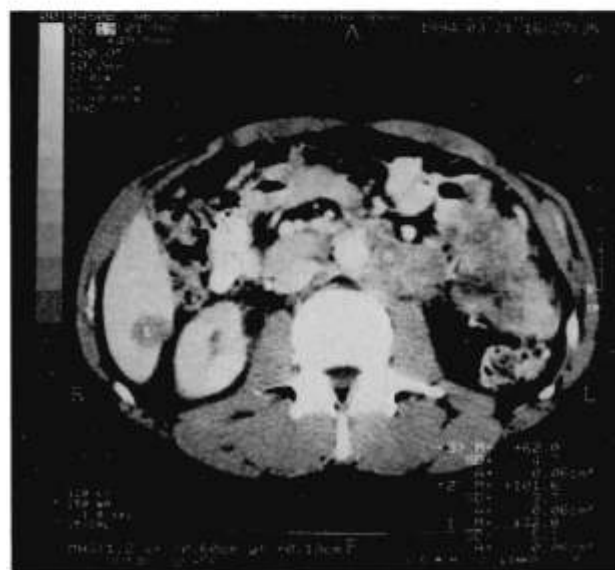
Case 2: abdominal and pelvic CT. (a) Multiple heterogeneous enhanced soft tissue masses and lymph nodes metastases in the pelvic cavity. External compression of the rectum and trigone of the bladder are seen. (b) Masses in left lower and mid-abdomen and lymph node metastases in para-aortic, peripancreatic and hepatoduodenal nodes. Liver metastasis is also noted.
